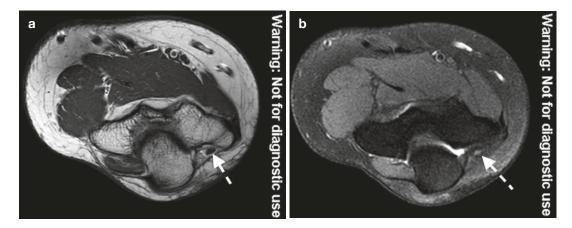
MRI of the ulnar nerve (*dashed arrow*) within the cubital tunnel at the elbow on axial (a) T1 and (b) T2FS
